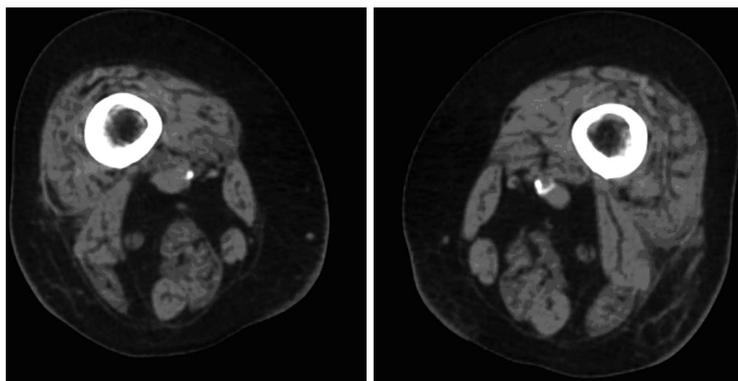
Cross-sectional computed tomography at the level of the middle thigh showing fatty degeneration and atrophy of skeletal muscles in a vitamin D-deficient patient.
